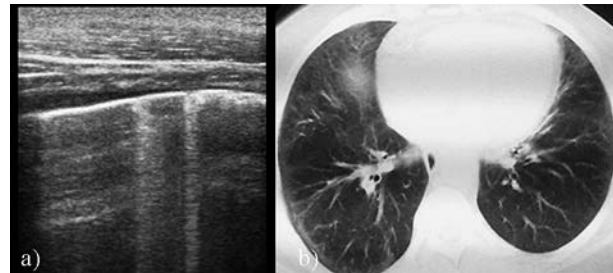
a) The comet tail sign (2 B-lines) in the mild form of alveolo-interstitial involvement in systemic sclerosis. b) HRCT showing the mild form of alveolo-interstitial involvement in systemic sclerosis (Warrick score=4).
